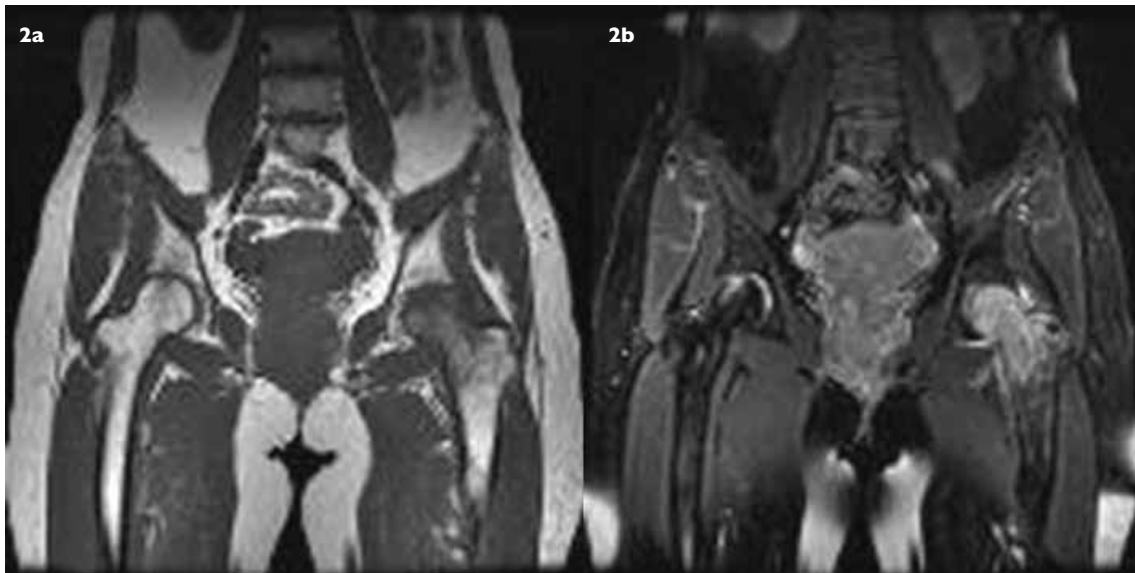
Case 1. (a) Coronal T1-W MR image shows uniformly decreased signal intensity in the left femoral head and neck. (b) Coronal T2-W MR image shows hyperintensity typical of bone marrow oedema extending up to the intertrochanteric region. Joint effusion is also well visualised.
